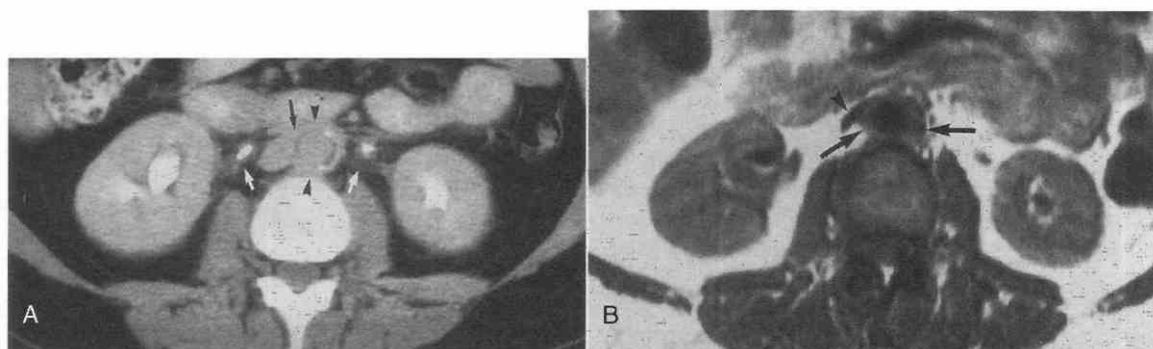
Idiopathic retroperitoneal fibrosis. *A*, A rim of fibrous tissue (*arrowheads*) surrounds the aorta, which contains calcified atherosclerotic plaques. The fibrous tissue obscures the plane between the aorta and the vena cava (*black arrow*). Fibrous tissue strands (*white arrows*) extend laterally to surround the ureters, which contain stents. There is bilateral calyceal dilatation. *B*, Proton-density weighted MR image (spin-echo, TR = 1800 msec, TE = 15 msec) obtained 6 months after bilateral ureterolysis reveals a periaortic rim of fibrous tissue (*arrows*) with a signal intensity higher than that of muscle. The inferior vena cava (*arrowhead*) is patent but is attached to the fibrous tissue.
